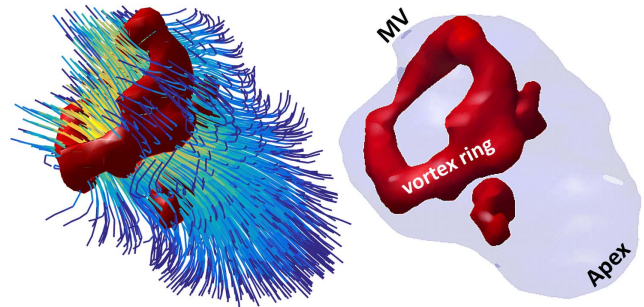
Image of the vortex ring forming in the left ventricle during early filling obtained by 4-D flow MRI. MV—mitral valve. The red isosurfaces delimit the regions of strong vorticity. The streamlines of the left panel show the flow direction in the left ventricular cavity.
